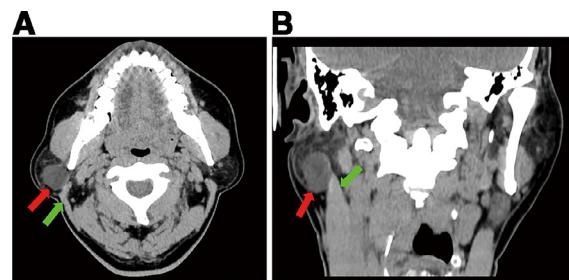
Typical computed tomography (CT) image features. (A) Axial CT scan. (B) Coronal CT scan. Typical CT image of clinically benign tumor (red arrow) in the parotid tail and its relationship with sternocleidomastoid muscle–parotid space (green arrow), with typical image of “shot put” sign in the axial plane and “dolphin lift ball” sign in coronal plane.
